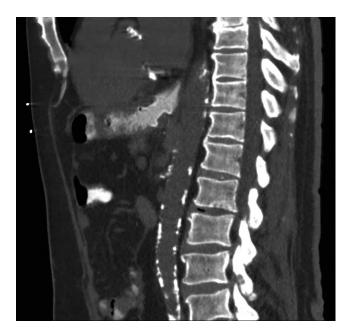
CT scan showing patent stent, with contrast passing from the esophagus into the jejunal limb without evidence of leak.
